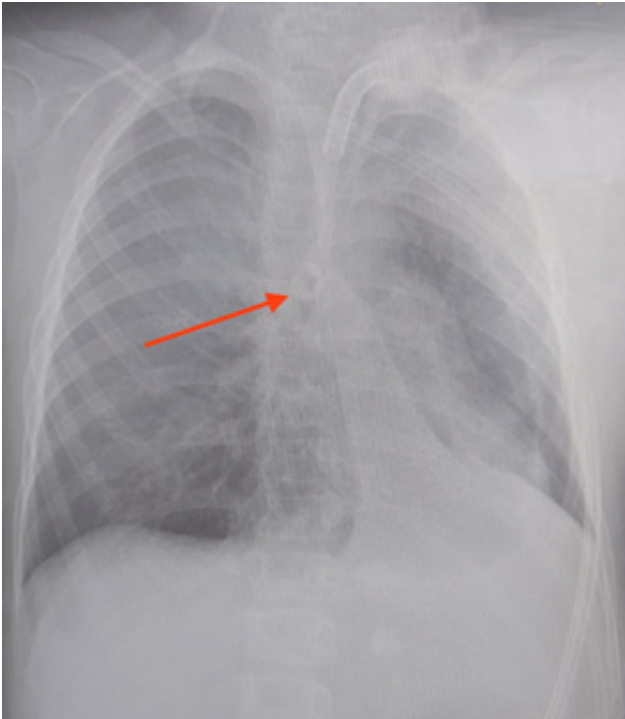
The radiopaque round middle part radiolucent image in the area corresponding to the right main bronchus on direct X-ray
